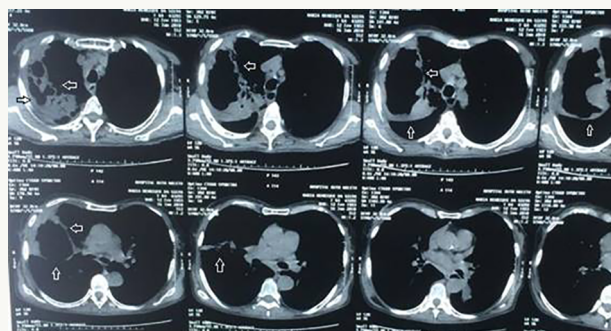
Chest CT coronal view – Large cavity lesion approximately 12cm in diameter, thick and irregular walls, adherent to the right chest wall, with extensive pleural infiltration and liquid content inside, doing hydro level (arrow).
